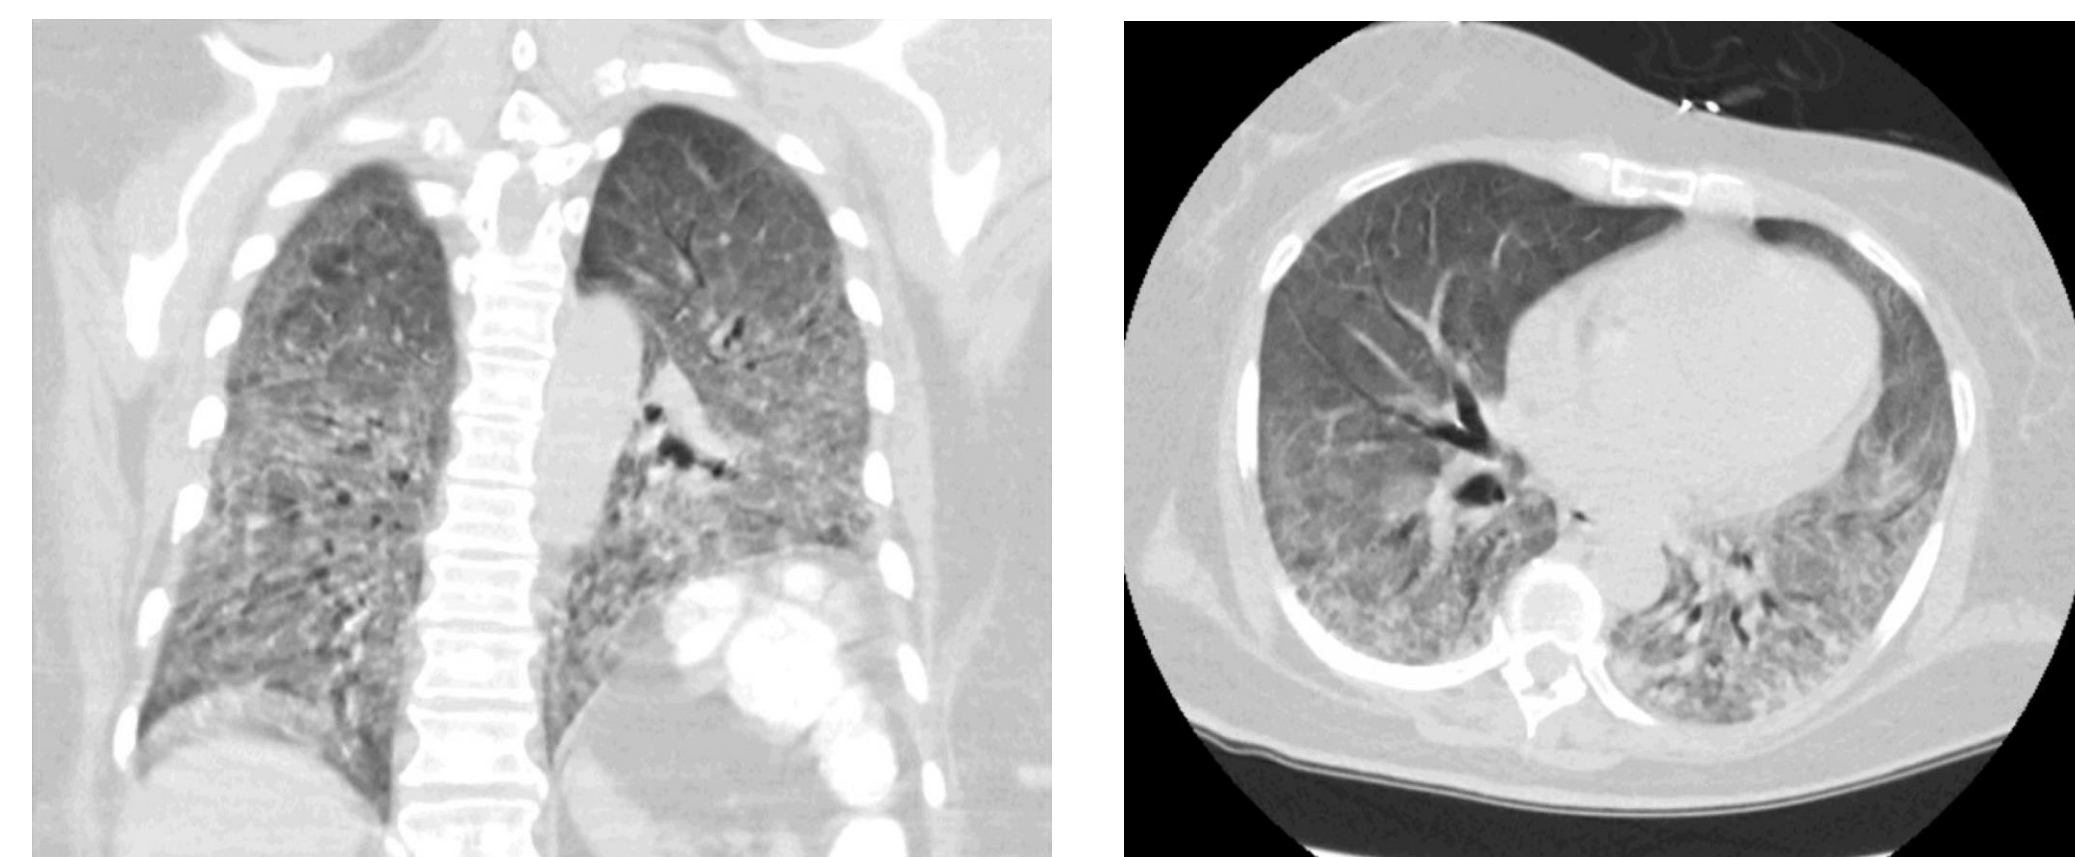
CT Chest AP and transverse view: Revealing diffuse ground glass opacities
